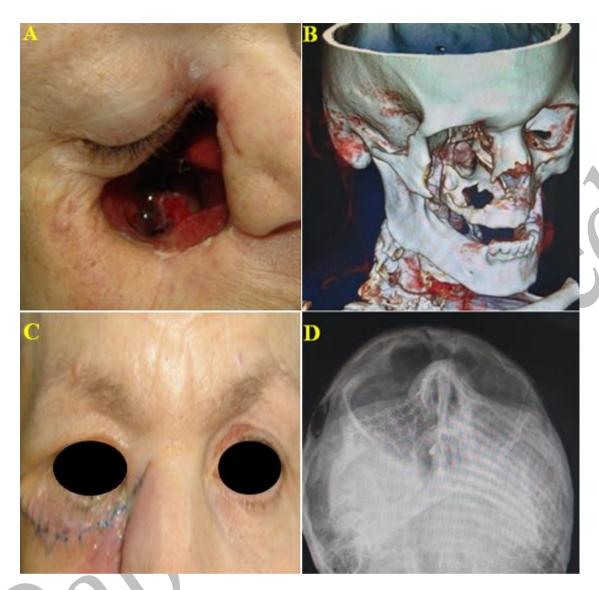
Reconstruction of the defect of the right maxilla six months after first treatment; A) clinical appearance of the defect; B) 3D reconstruction of the defect of the right maxilla; C) postoperative appearance of the patient after reconstruction of the floor of the orbit and skin; D) control radiographic picture
